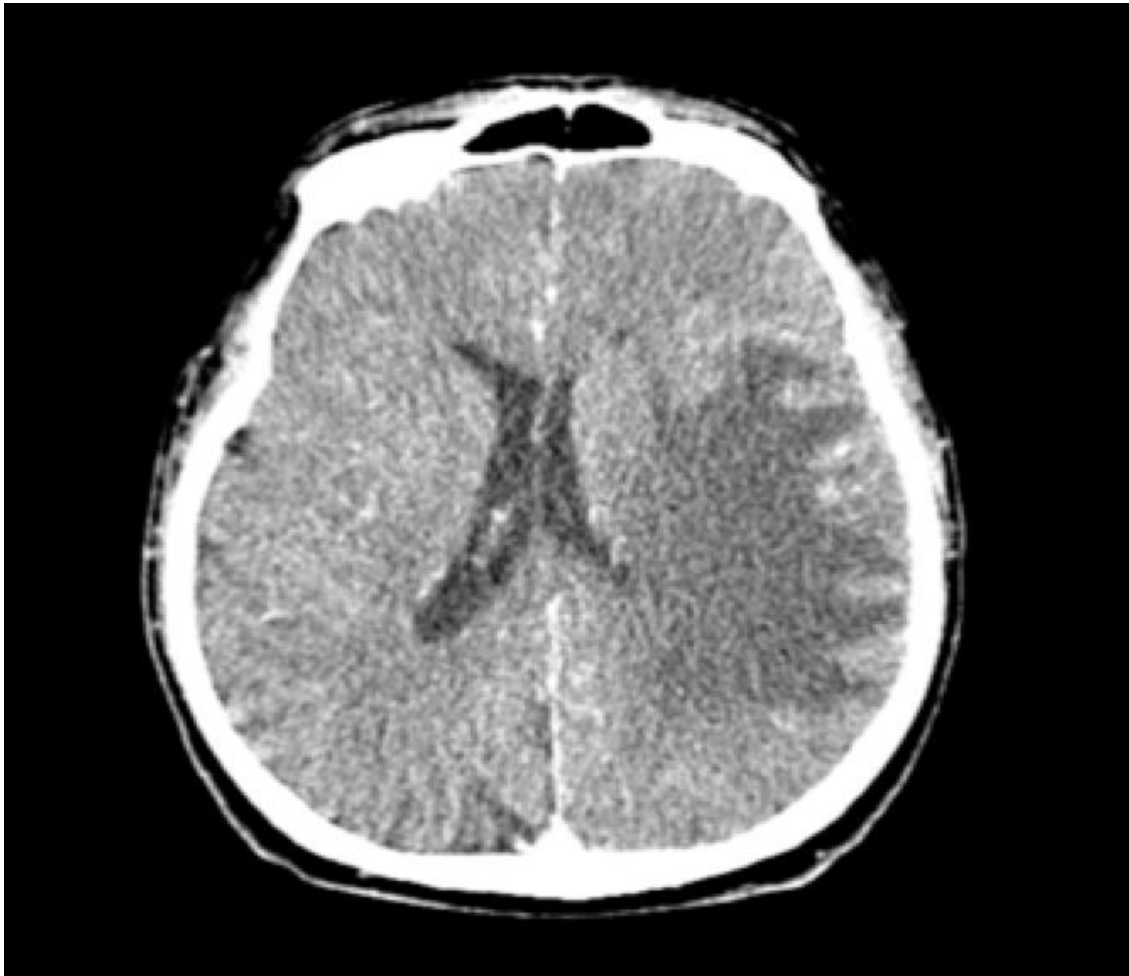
An axial image of contrast enhanced computed tomography scan of the brain shows subcortical and deep white matter oedema of the left fronto-parietal lobes sparing the cortical grey matter. No obvious enhancing mass. Minimal regular thickened leptomeningeal enhancement present at its periphery.
